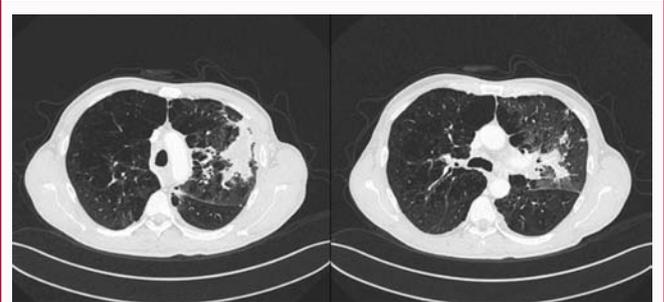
Images in a 59-year-old man who presented with recurrent syncopal episodes preceded by dizziness. Axial thin-section unenhanced CT scan shows extensive area of consolidation at the level of the left upper lobe referable to the newly formed process.
